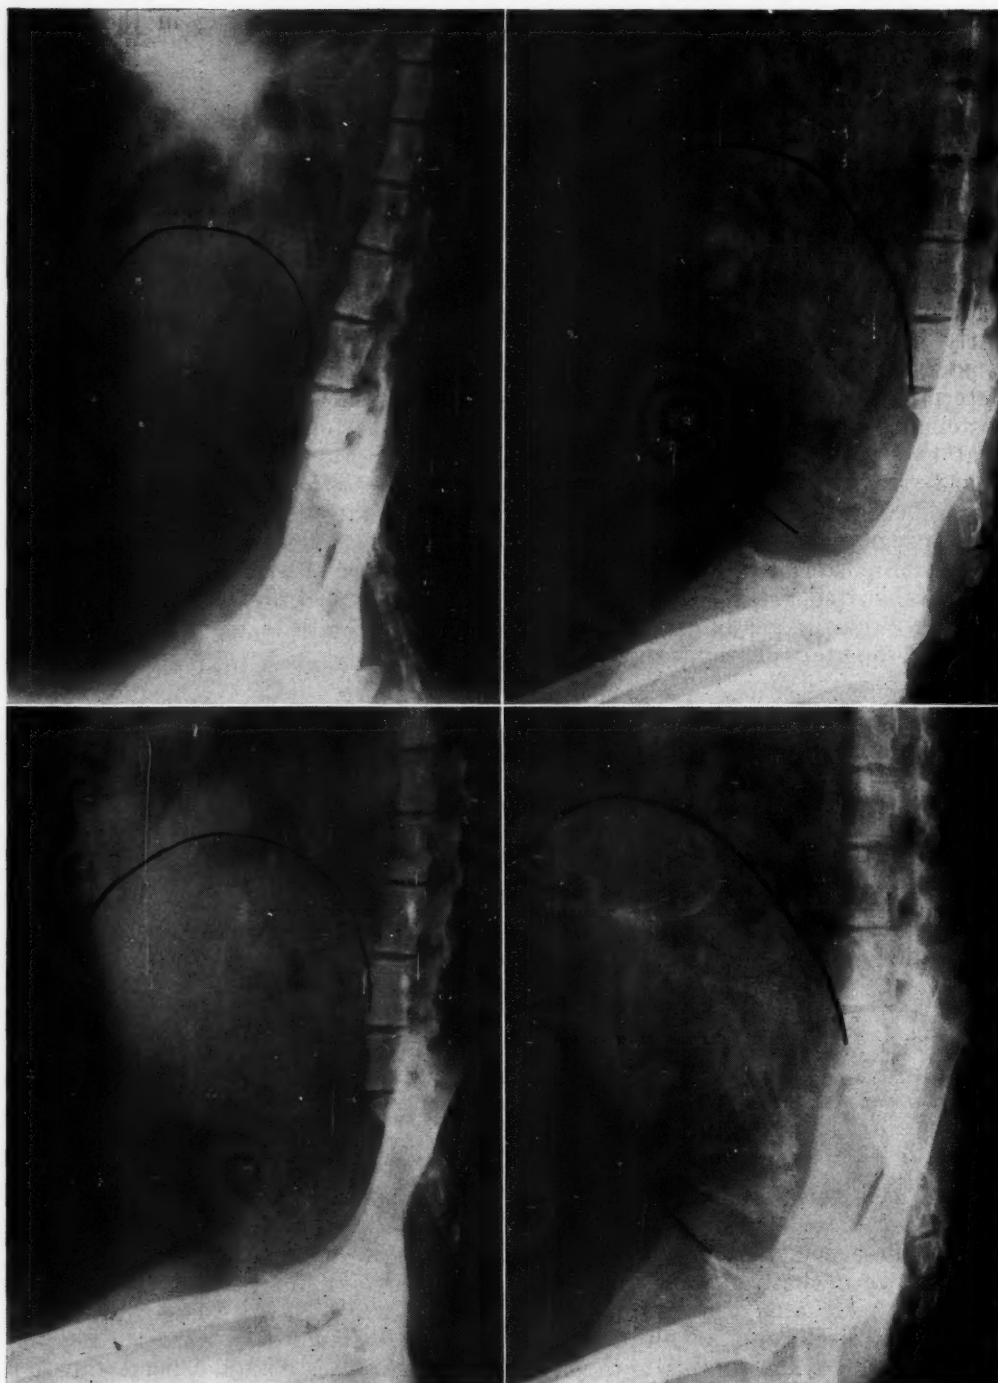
Lateral soft tissue x-rays of uteri at progressive intervals through gestational period. The general appearance before the 100th day is spherical and thereafter becomes cylindrical. The radiopaque markers are visible in some plates. It has been necessary to ink in outlines because of loss of contrast in photography and reduction. Upper left, 59 days, upper right, 78 days, lower left, 99 days, lower right 104 days.
